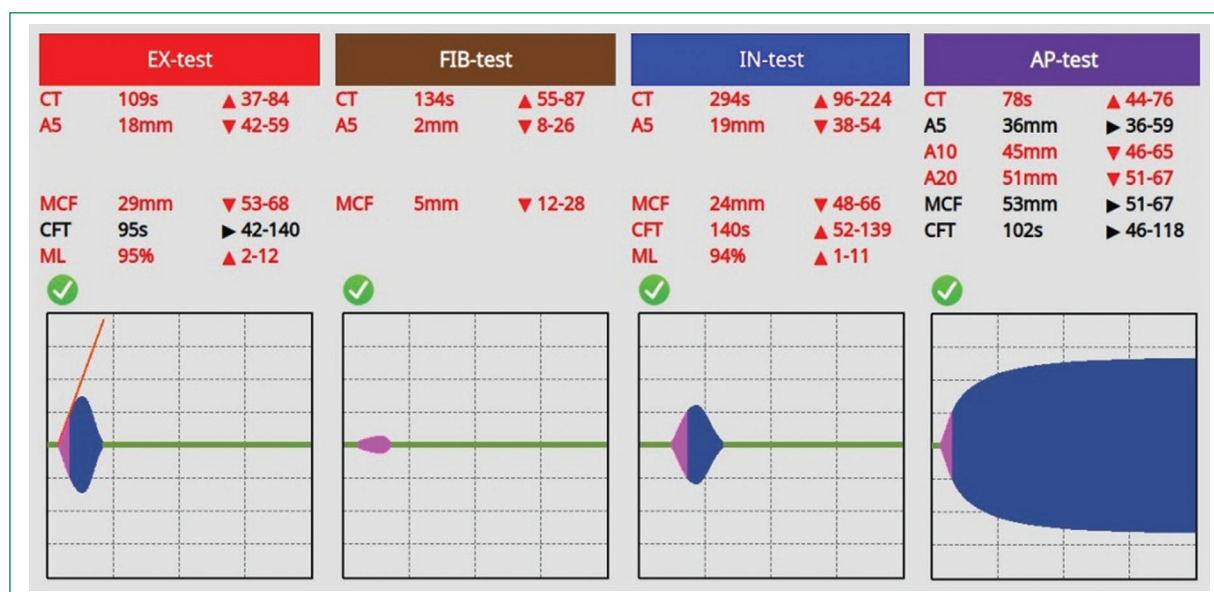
Representation of fulminant hyperfibrinolysis in ClotPro®. A(x): amplitude after (x) minutes; CFT: clot formation time; CT: coagulation time; MCF: maximum clot firmness; ML: maximum lysis.
